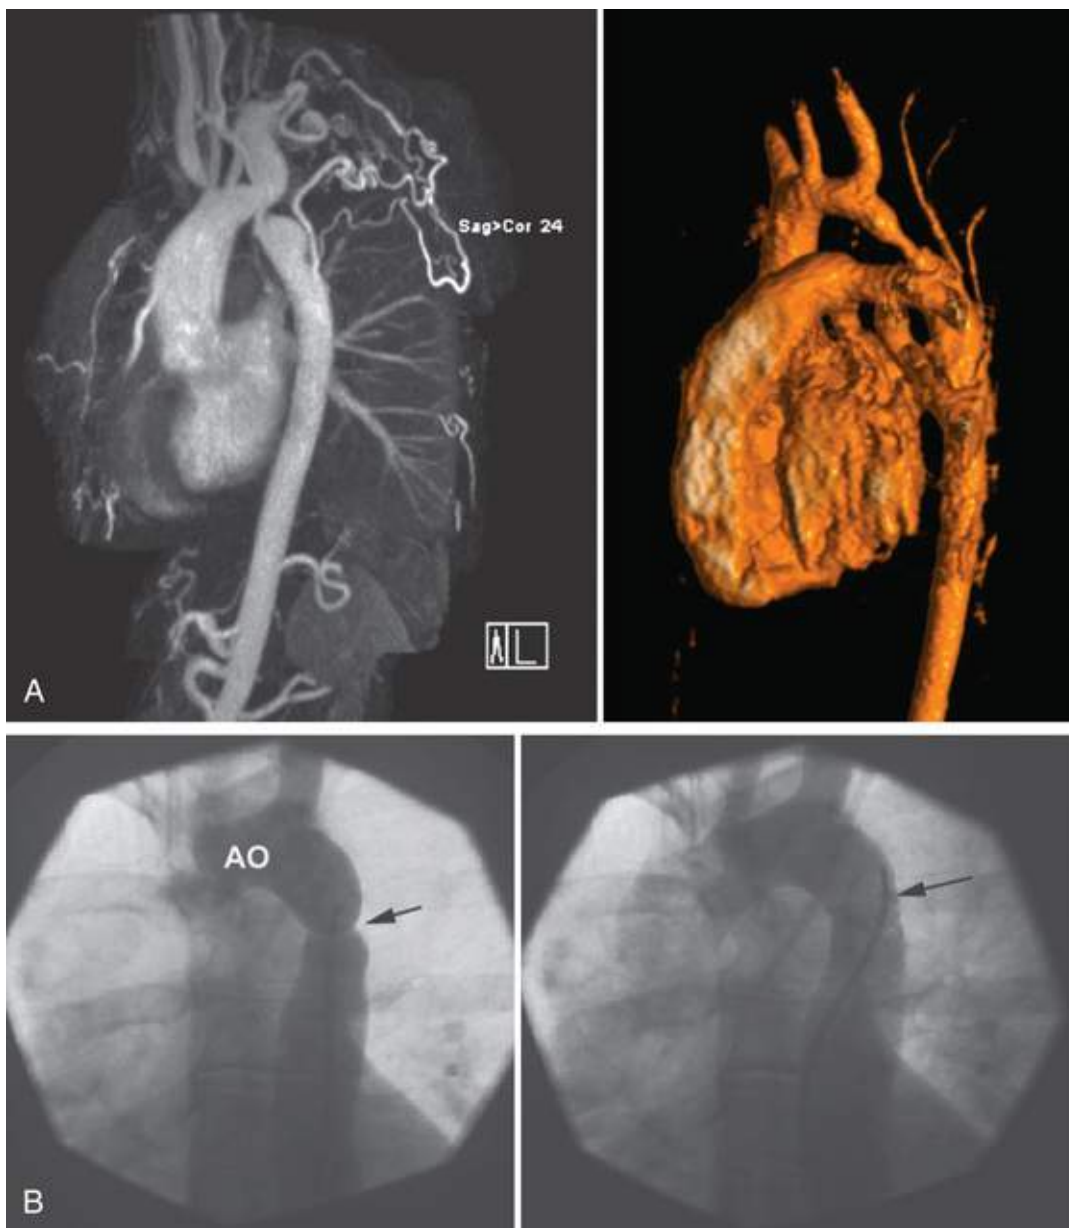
A, Montage of coarctation of the aorta. The left image shows the site of the posterior shelf. The right image is from an MRI and shows the posterior shelf and some associated transverse arch hypoplasia. B, Angiogram of coarctation of the aorta, before and after stenting. AO, aorta.
